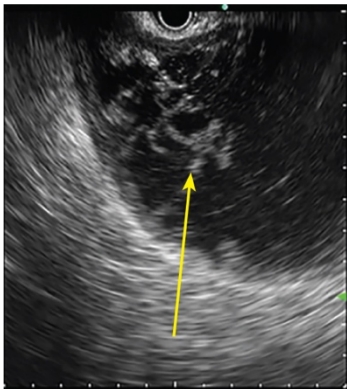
Endoultrasoundography of pancreatobiliary area
